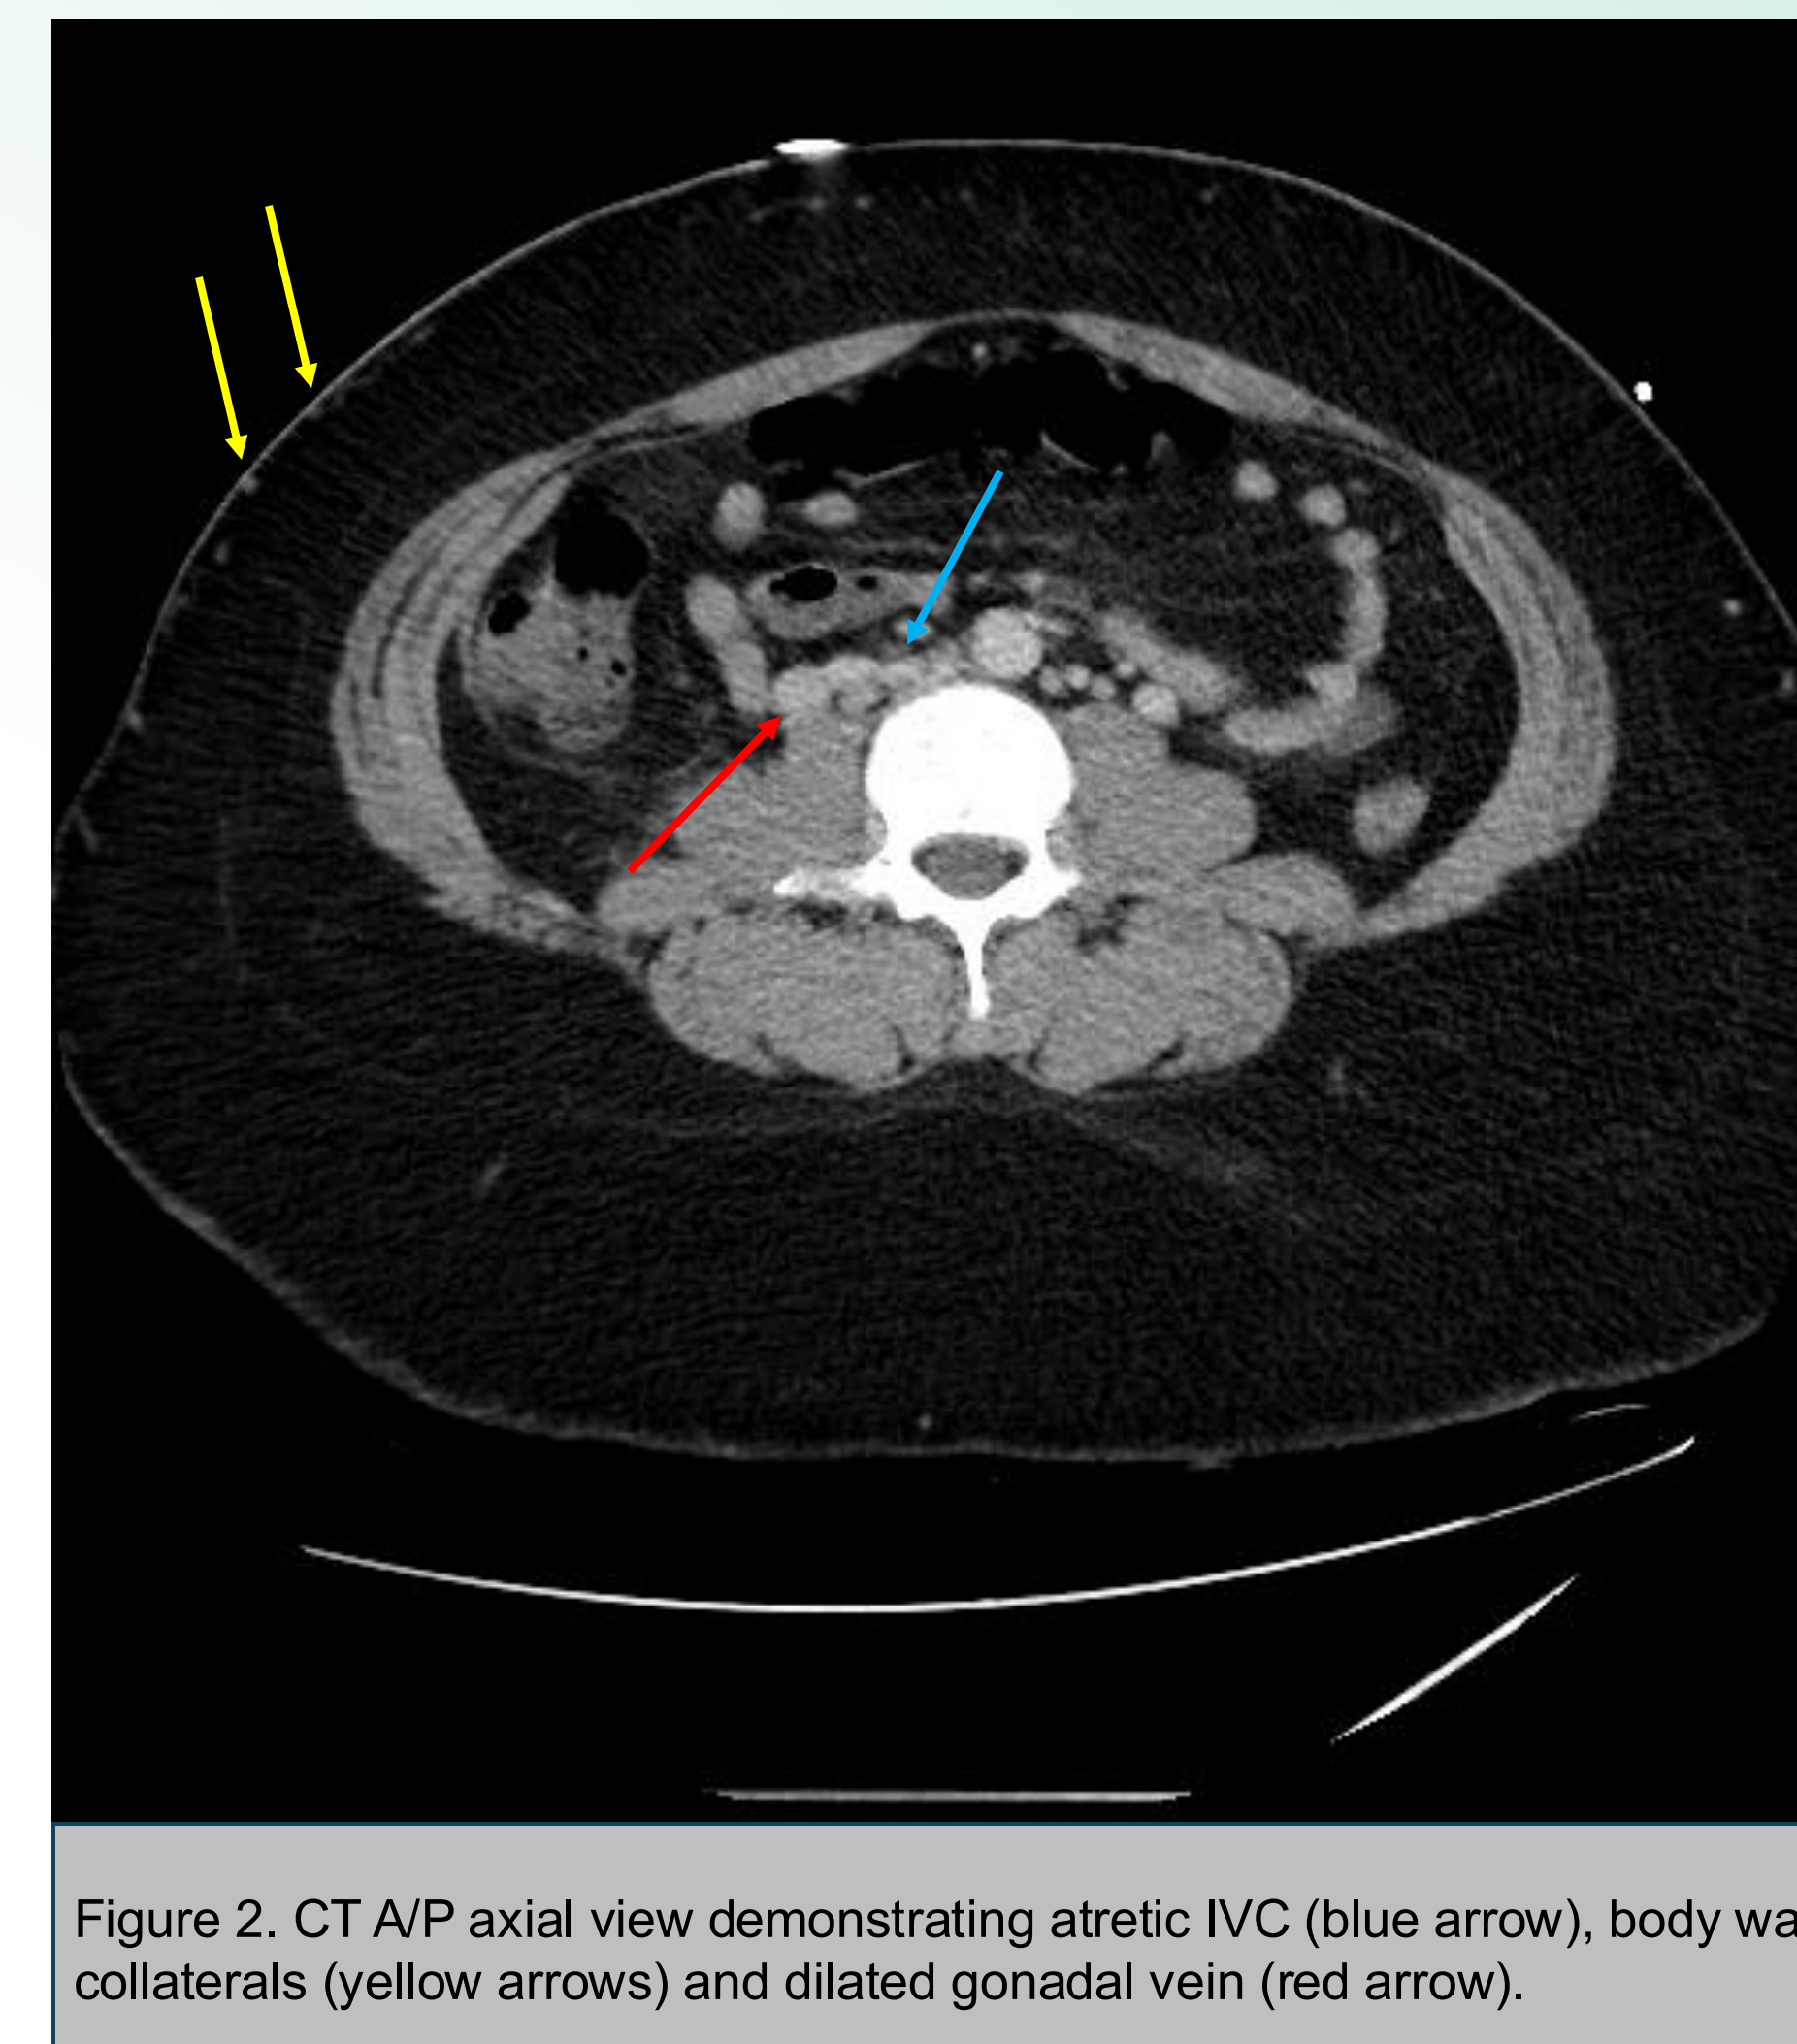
CT A/P axial view demonstrating atretic IVC (blue arrow), body wall collaterals (yellow arrows) and dilated gonadal vein (red arrow).
